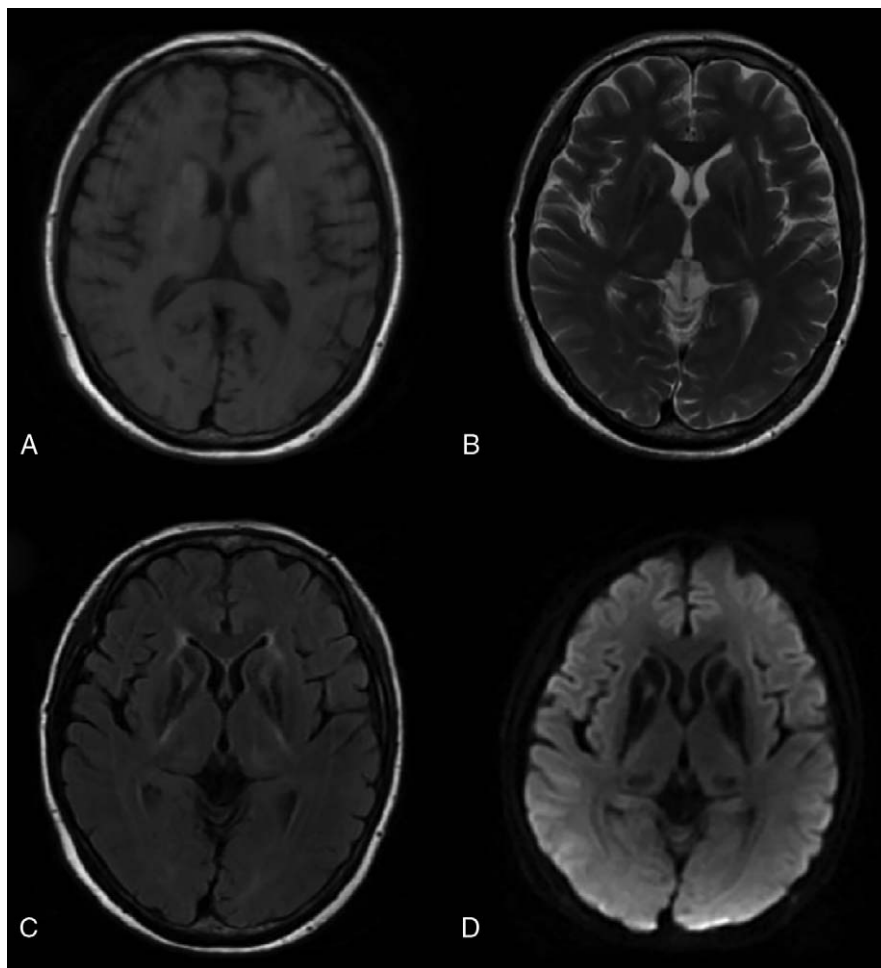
Axial brain magnetic resonance imaging of the patient with abnormal lesions in bilateral caudate nucleus, shell, and thalamus. (A, B) T1-weighted and T2-weighted images revealed increased signal intensity in bilateral caudate nucleus, shell, and thalamus. (C) Fluid-attenuated inversion recovery-weighted image shows high-intensity signal in the peripheral region and low-intensity signal in the internal region of the bilateral caudate nucleus, shell, and thalamus. (D) Diffusion weighted imaging shows low-intensity signal of the bilateral caudate nucleus, shell, and thalamus.
